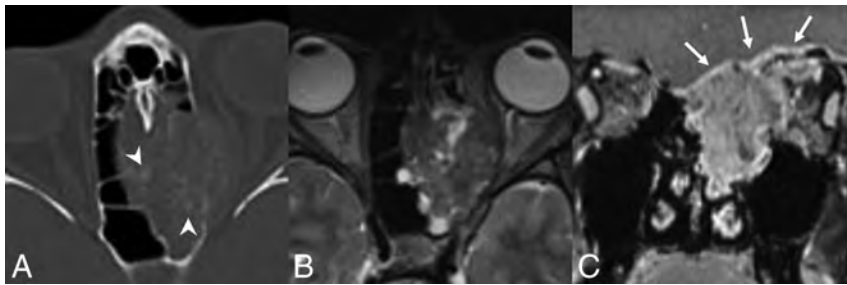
NUT carcinoma. A, Axial noncontrast CT image shows a locally destructive mass centered within the left ethmoid sinus extending into the left orbit and laterally displacing the medial rectus muscle. There is faint mineralization within the mass (white arrowheads). Axial T2 fat-saturated (B) and coronal T1 postcontrast, fat-saturated (C) MR images from the same patient show the mass to be heterogeneous but predominantly hypointense to the cortex on T2WI and avidly enhancing. The mass extends into the anterior cranial fossa with dural involvement (white arrows). Images are courtesy of Dr Nafi Aygun, Johns Hopkins Hospital.
